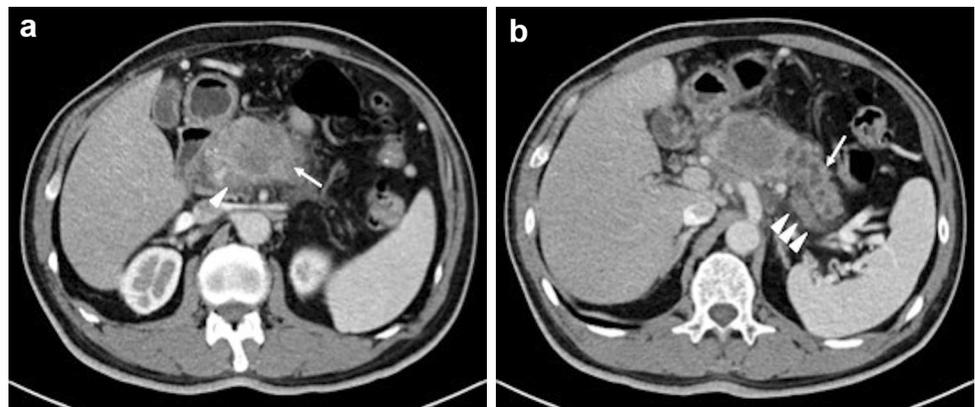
Axial CT scans in a 64-year-old man with a 4.8-cm PASC lesion in the pancreatic body. a Axial CT image during the portal venous phase showing a solid mass with rim enhancement (arrow) and a tumor thrombus in the splenic vein (arrowhead). b Axial CT image during the equilibrium phase showing a filling defect in the splenic vein (arrowhead), behind the upstream ductal dilation (arrow)
